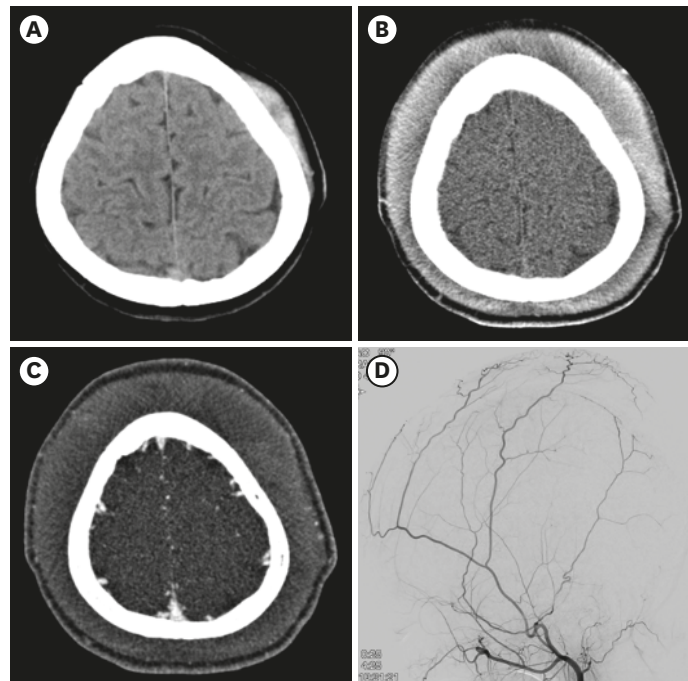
CT scans and external carotid angiogram of a 12-year-old boy. A localized SGH on the left parietal developed after hair pulling (A). In the 3rd day after the minor trauma, diffuse SGH suddenly developed (B). No leaks of the contrast dye are noted in the CT angiogram (C). In the external carotid angiogram, no vascular fistula or abnormality can be found (D).
